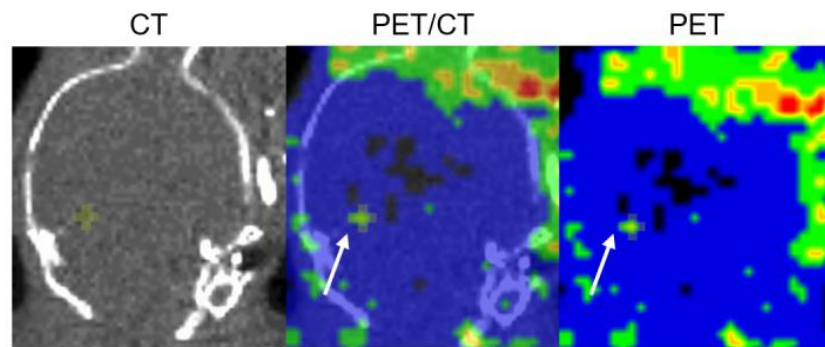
Visualization of manual segmentation in PET/CT
